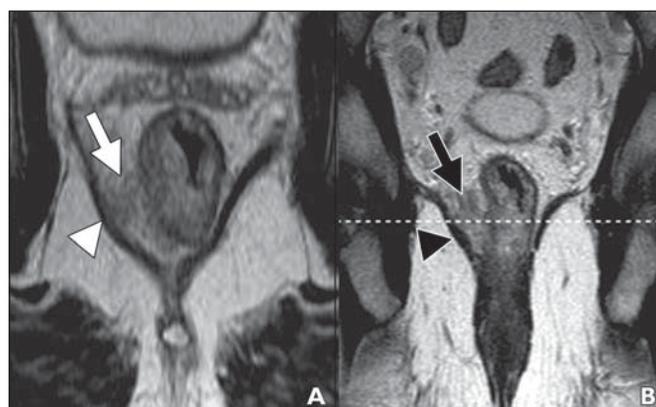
80-year-old man with rectal cancer. A, Baseline axial T2-weighted MR image shows semiannular infiltrating tumor (*arrow*) between 7- and 9-o'clock positions. Tumor extends extramurally and is less than 1 mm from left levator muscle (*arrowhead*). Potential resection margin is therefore threatened. B, Baseline coronal T2-weighted MR image shows extramural tumor extension (*arrow*) up to left levator muscle (*arrowhead*). Dashed line indicates localiser.
